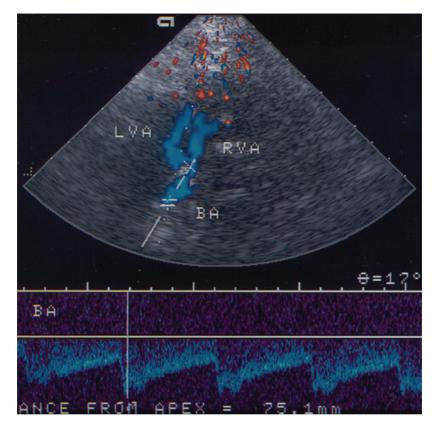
TCCD frame obtained from the vertebral and basilar arteries via the transforaminal acoustic window. Doppler spectra are obtained from the proximal basilar artery.
